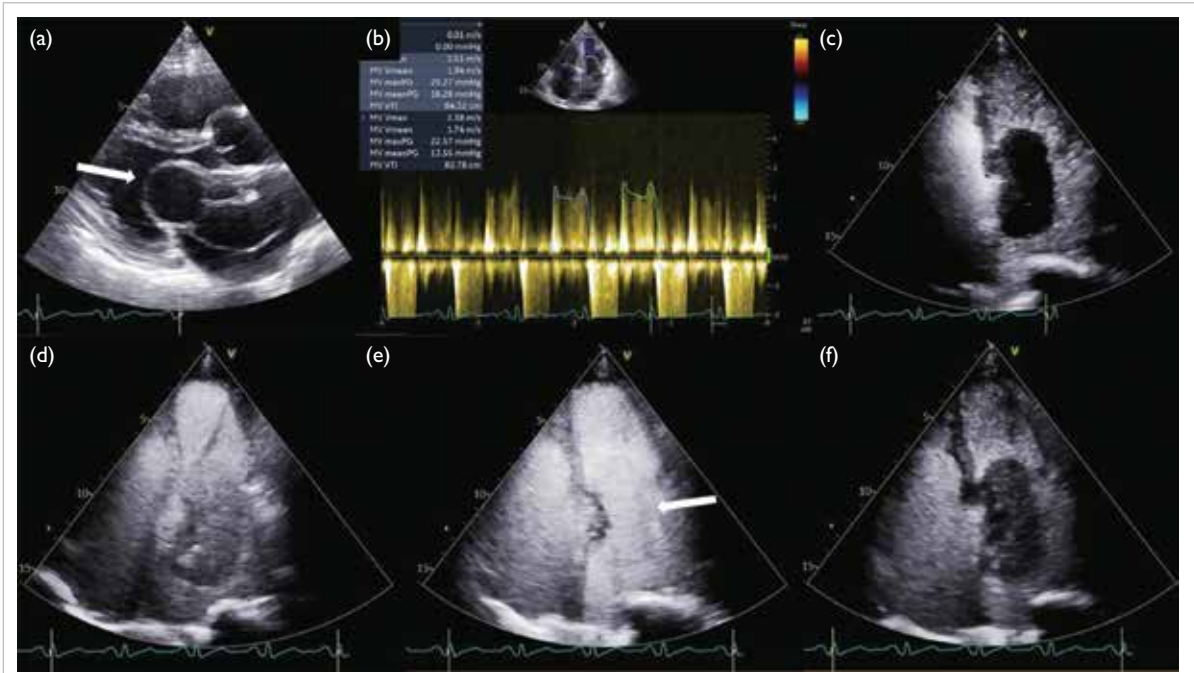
Two-dimensional transthoracic echocardiographic examination of the cardiac mass of the patient. (a) Double-barrel-shaped left atrial myxoma with central echolucent space (arrow). (b) Doppler mitral inflow showing significant gradient across mitral valve. (c) Early contrast phase showing enhancement of the stalk of cardiac myxoma. (d) Delayed contrast enhancement of echolucent space. (e) Homogeneous opacification of previous echolucent space of the cardiac myxoma (arrow). (f) Early contrast washout prior to the cardiac chambers
